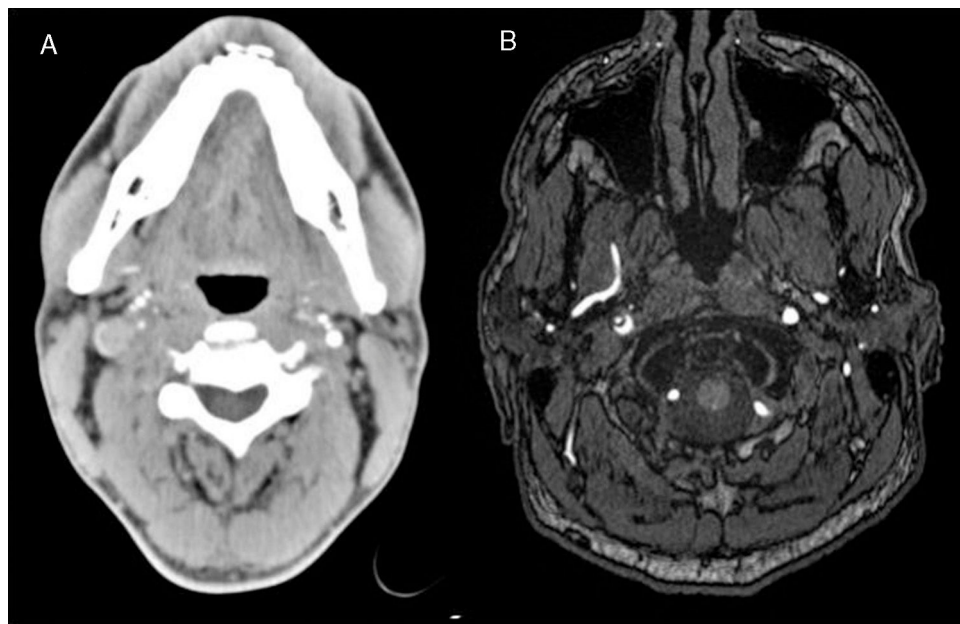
(A) CT angiography showing reduced blood flow in the right internal carotid artery at the level of the cervical spine. (B) MRI angiography (time-of-flight sequence) showing reduced blood flow in the same artery (this sequence was taken at a higher level than the CT angiography sequence) and a false lumen in the medial region.
